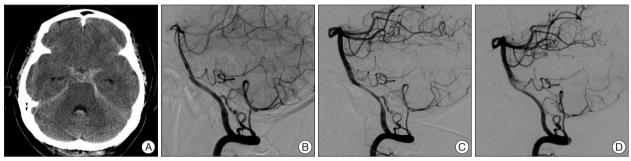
Coiling case 3. A 46-year-old female presents with subarachnoid hemorrhage due to a ruptured posterior inferior cerebellar artery (PICA) aneurysm which is located in the tonsillo-medullary segment. A : Preoperative CT shows a hemorrhages in the peri-mesencephalic and both Sylvian fissure, and acute hydrocephalus. B : Lateral projection angiogram shows the aneurysm arising from the tonsillo-medullary segment of the left PICA. C : Post-coiling angiogram shows slight contrast filling within the body of aneurysm due to kick back of microcatheter. D : Fourteen-month follow-up angiogram demonstrates no contrast filling within the aneurysm.
